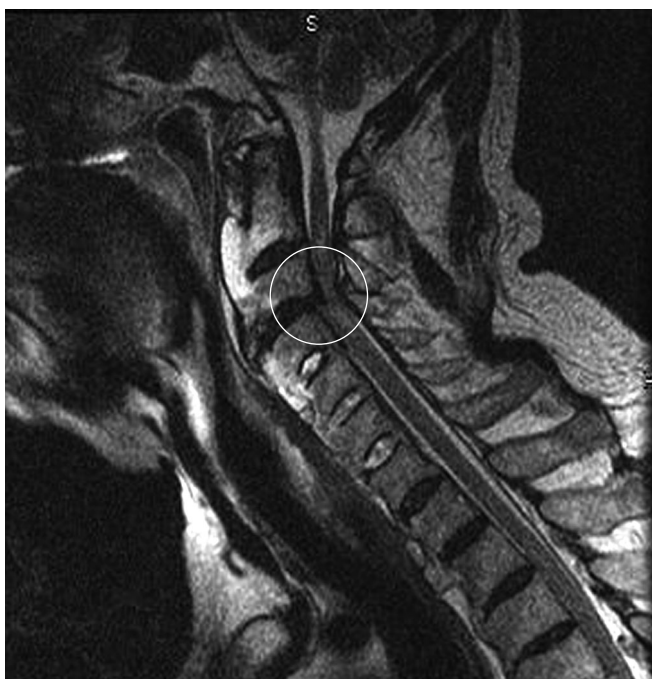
Sagittal T2-weighted MR image of the cervical spine shows a herniated nucleus pulposus at C3-C4 causing a change in the signal intensity of the spinal cord, stenosis of the central canal, and effacement of the ventral cerebrospinal fluid space (*circle*).
